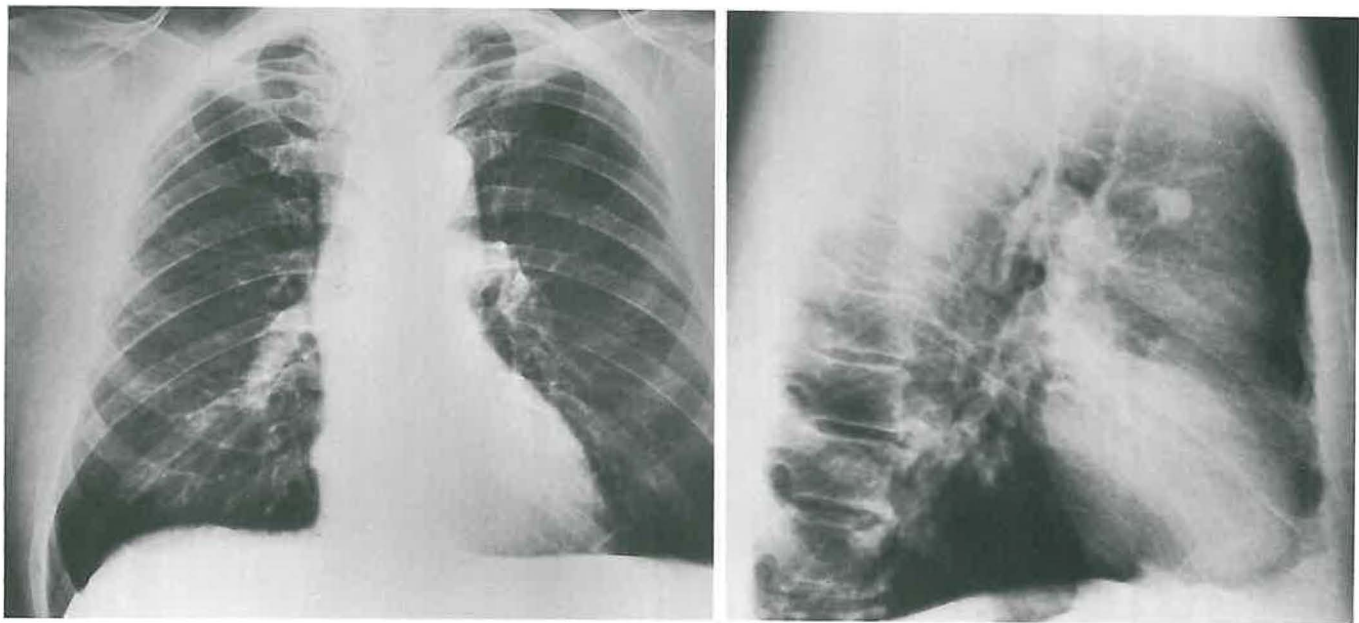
Adenosquamous carcinoma of the left upper lobe in a 65-year-old white man. There were no symptoms, and the lesion was found in a routine chest examination which fortunately included posteroanterior and left lateral views. In the P-A roentgenogram, the lesion was not seen because its shadow was superimposed on the shadow of the left hilum. The shadow of the lesion is readily seen in the lateral view.
